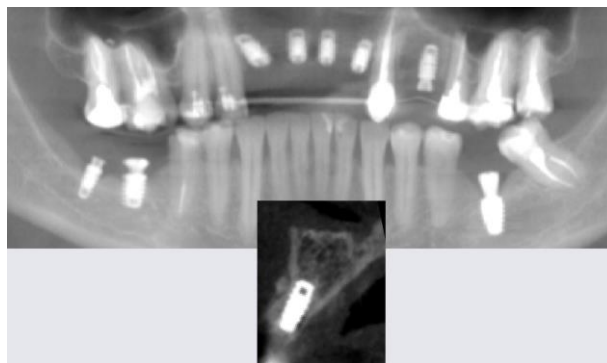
The 6 months postoperative computed tomography shows the optimal placement of implants.
